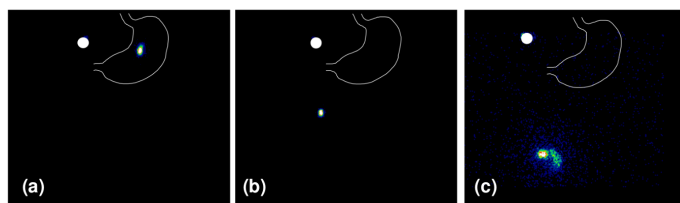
Representative scintigraphic images showing (a) formulation in stomach immediately post dose, (b) post gastric emptying, (c) dispersion of Tc label
